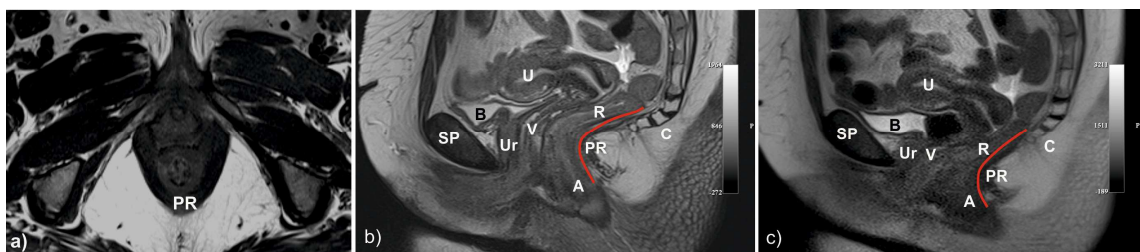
Magnetic Resonance images in the axial (a), sagittal (b) plane acquired at rest position, and during maximal Valsalva manoeuvre (c). The main pelvic organs are identified (A - anus; B - bladder; C - coccyx; PR - puborectal muscle; R - rectum; SP - *symphysis pubis*; U - uterus; Ur - urethra V - vagina).
